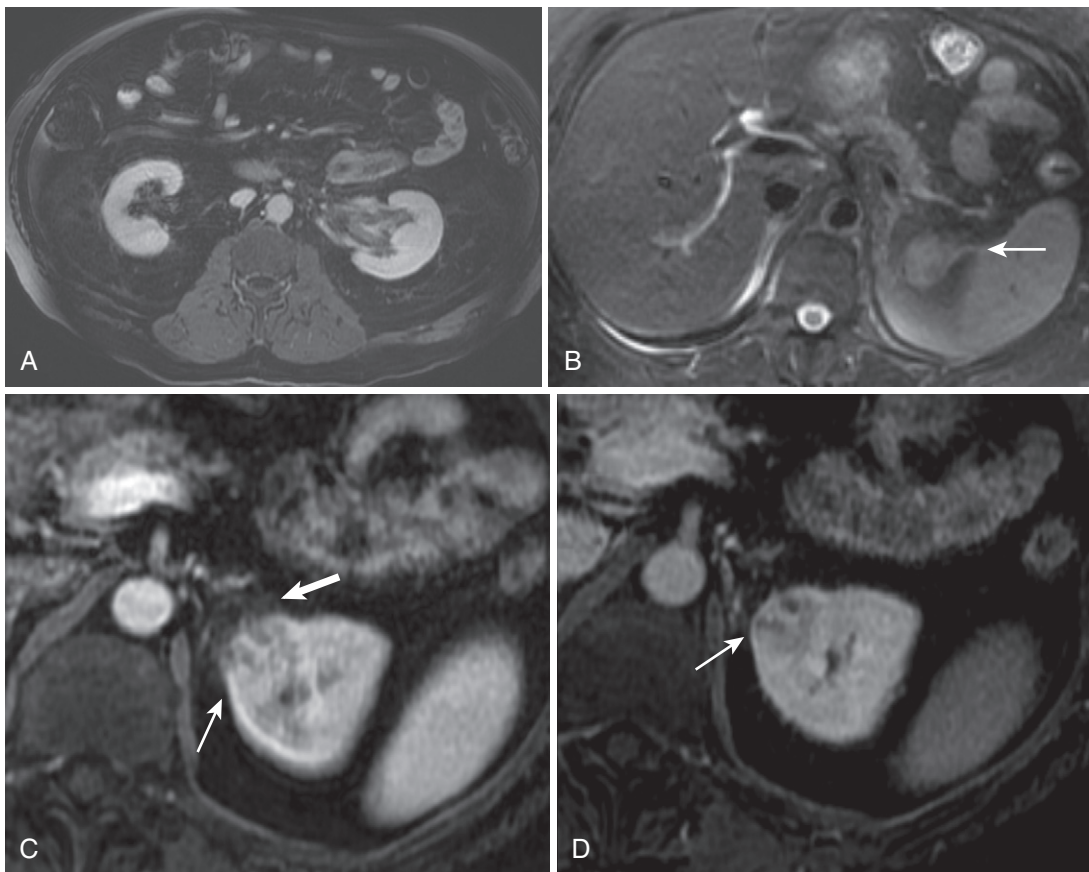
Acute pyelonephritis. The axial postcontrast image (A) shows infiltration of the left renal sinus fat and urothelial thickening and enhancement. The fat-suppressed T2-weighted image through the upper pole of the left kidney (B) shows perinephric edema (*arrow*). The early (C) and delayed (D) postcontrast images show an evolving pyogenic abscess (*thin arrow*) with perinephric inflammation (*thick arrow* in C) and dilated tubules with the striated nephrogram appearance.
